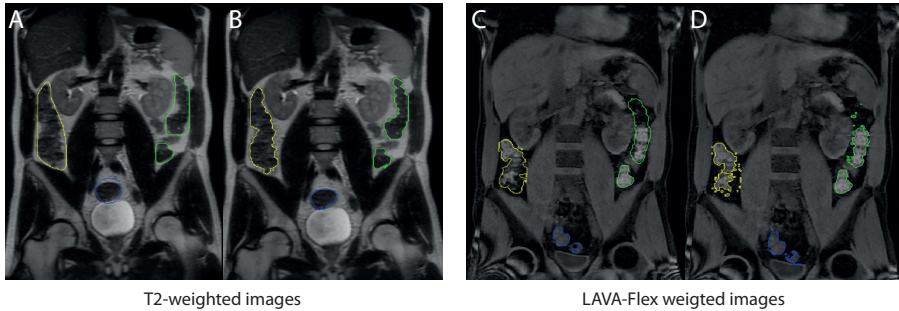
Classification of colonic volume and colonic content using a k-means clustering algorithm. Ascending colon is yellow, descending colon is green, and sigmoid colon is blue. A) Manual drawn region on a T2-weighted image. B) Classified colonic volume on a T2-weighted image. C) Manual drawn region on a LAVA-Flex image. D) Classified colonic content on a LAVA-Flex image.
